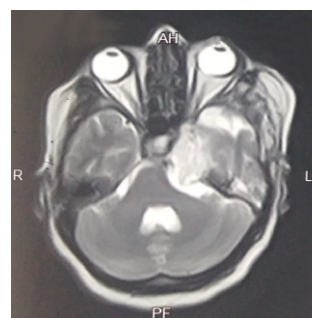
T2 weighted MRI image showing tumor close proximity with brain stem
